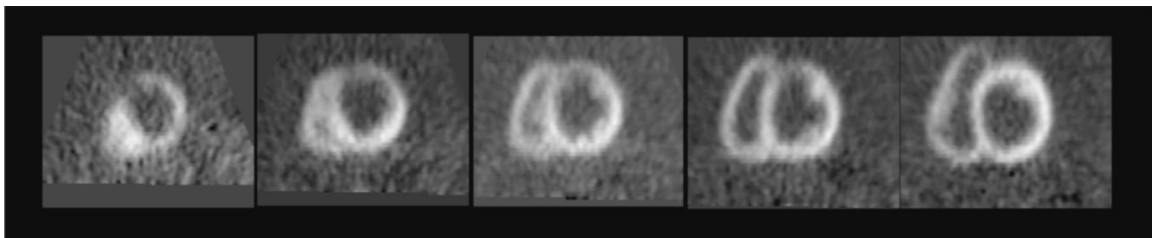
$^{18}\text{F}$ FDG Short axis slices from apex (on the left) to base (on the right).
